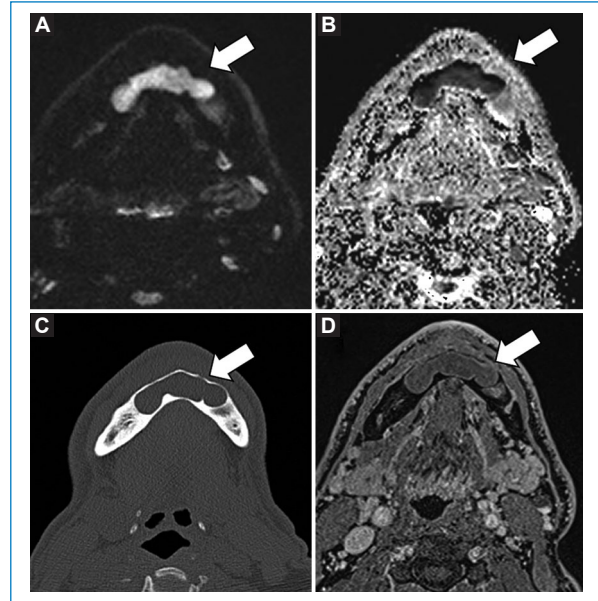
A and B: Siemens 1.5 T Axial RESOLVE diffusion. C: computed tomography with bone algorithm. D: T1-weighted image after gadolinium. Patient with Gorlin-Goltz syndrome. Mandibular keratocyst (arrow) showing intense diffusion restriction, expansive and lytic behavior on computed tomography, and absence of enhancement.
